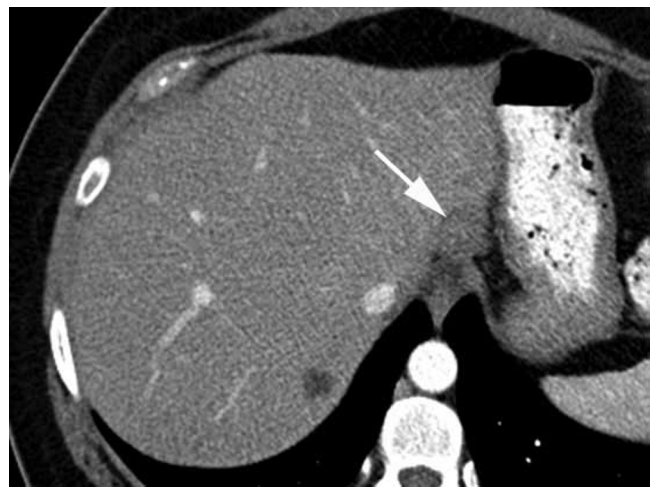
A 53-year-old female with Cowden's syndrome whose FNH lesion (arrow) has regressed. An enhanced CT image taken 90 months after Figure 3 shows marked involution of the mass in segment 2 of the liver. The mass measures 2.1 x 1.9 cm.
